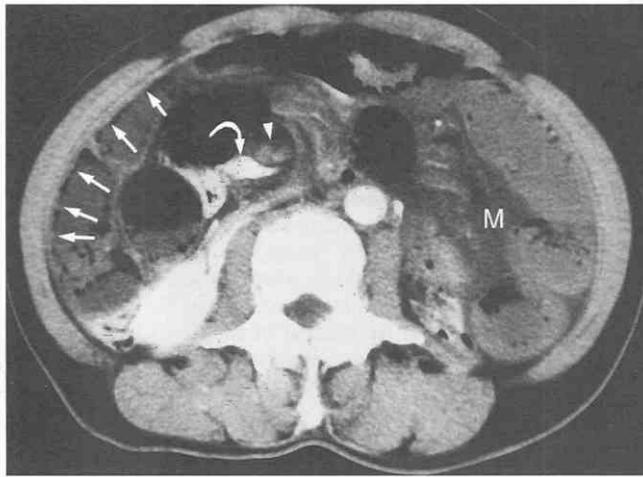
Strangulated small-bowel obstruction caused by bands and adhesion. Early phase of the spiral CT scan shows pneumatosis (arrows) and poor contrast enhancement in the strangulated segment of the small-intestinal loops. At the site just proximal to the obstruction, the superior mesenteric artery (arrowheads) is poorly opacified with contrast material as compared with the well-opacified superior mesenteric vein (curved arrow). Diffuse mesenteric haziness (M) is also noted. (From Ha HK, Rha SE, Kim JH, et al: CT diagnosis of strangulation in patients with small bowel obstruction: Current status and future direction. *Emerg Radiol* 2:47-55, 2000.)
